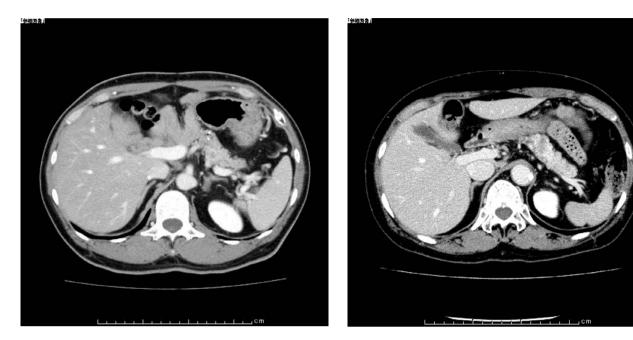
CT showing a low-density mass in the tail of the pancreas in case 1.
